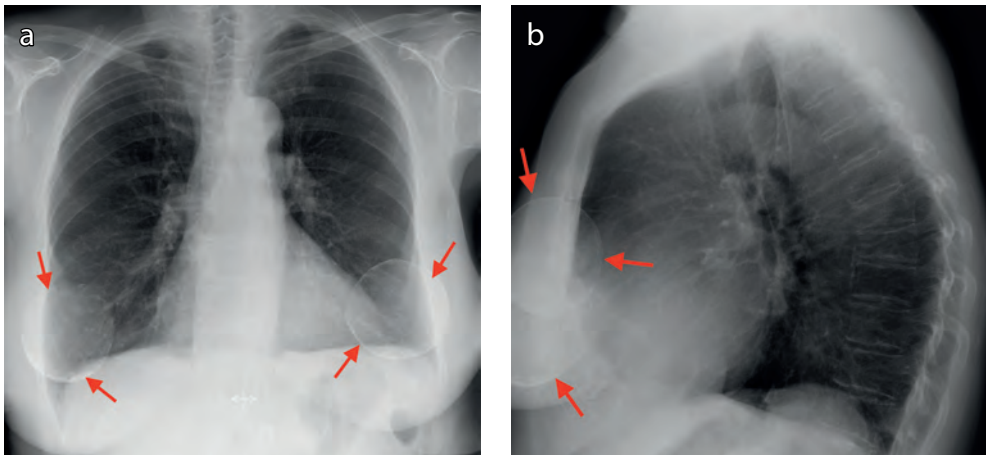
Standard chest radiograph in posterior-anterior (1a) and lateral (1b) view made in 70 year old female due to a suspicion of exacerbated lung emphysema). The implant can be seen by the evident calcifications in the periprosthetic capsule (arrows).
